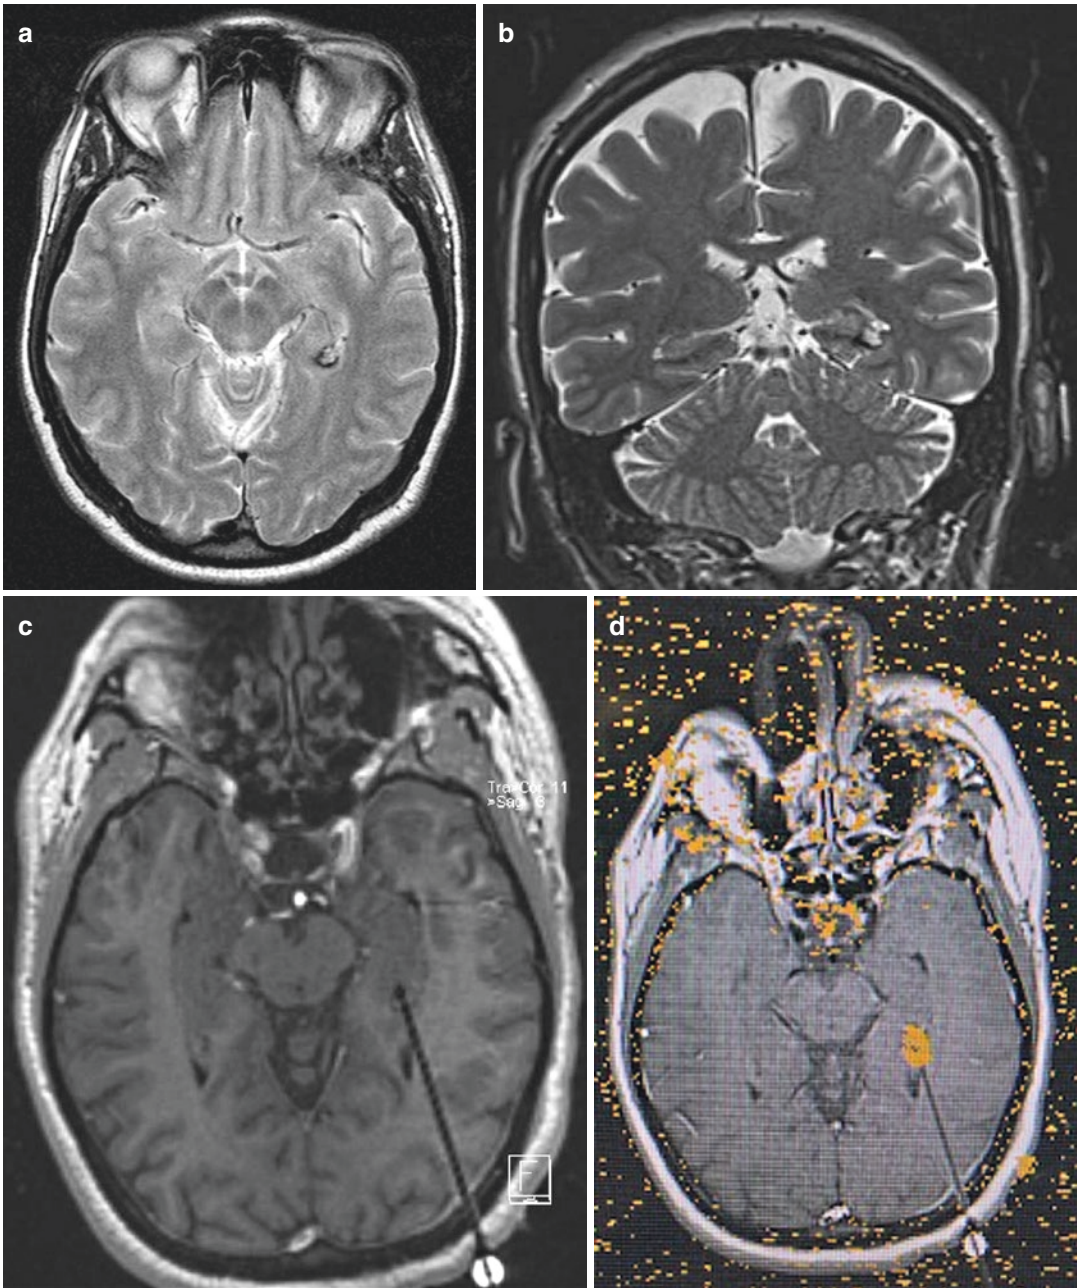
Laser Ablation of Cavernous Malformation. (a) Axial FLAIR MRI and (b) coronal T2 of cavernous malformation deep in the left temporal lobe adjacent to the tail of the hippocampus in a right-handed dominant young woman. Surgical approach for resection cannot be done without either significant incursion on the white matter
